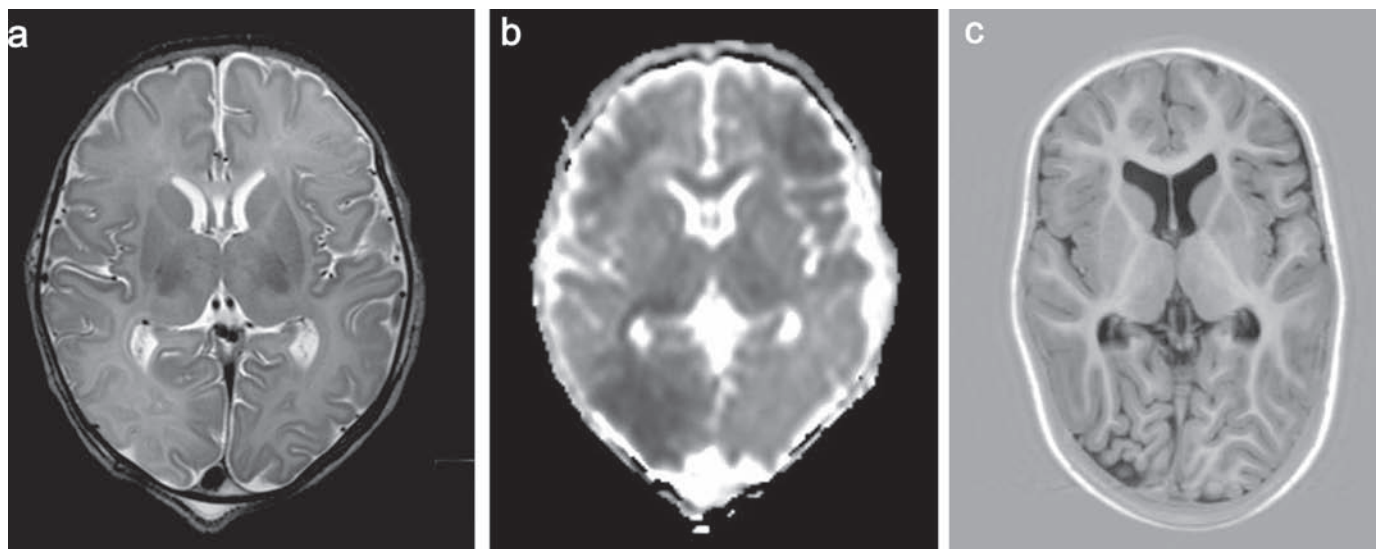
MRI on day 3 (A,B) and at 22 months (C) in an infant with WS injury. (A) T2 weighted spin echo sequence image showing loss of the cortical ribbon mainly in the left frontal and right parieto-occipital region. (B) Apparent diffusion coefficient map also showing involvement of the right anterior watershed region as well as the right optic radiation. (C) Inversion recovery sequence showing sequelae in the right occipital region. Outcome at 3 years is within the normal range (DQ 90).
